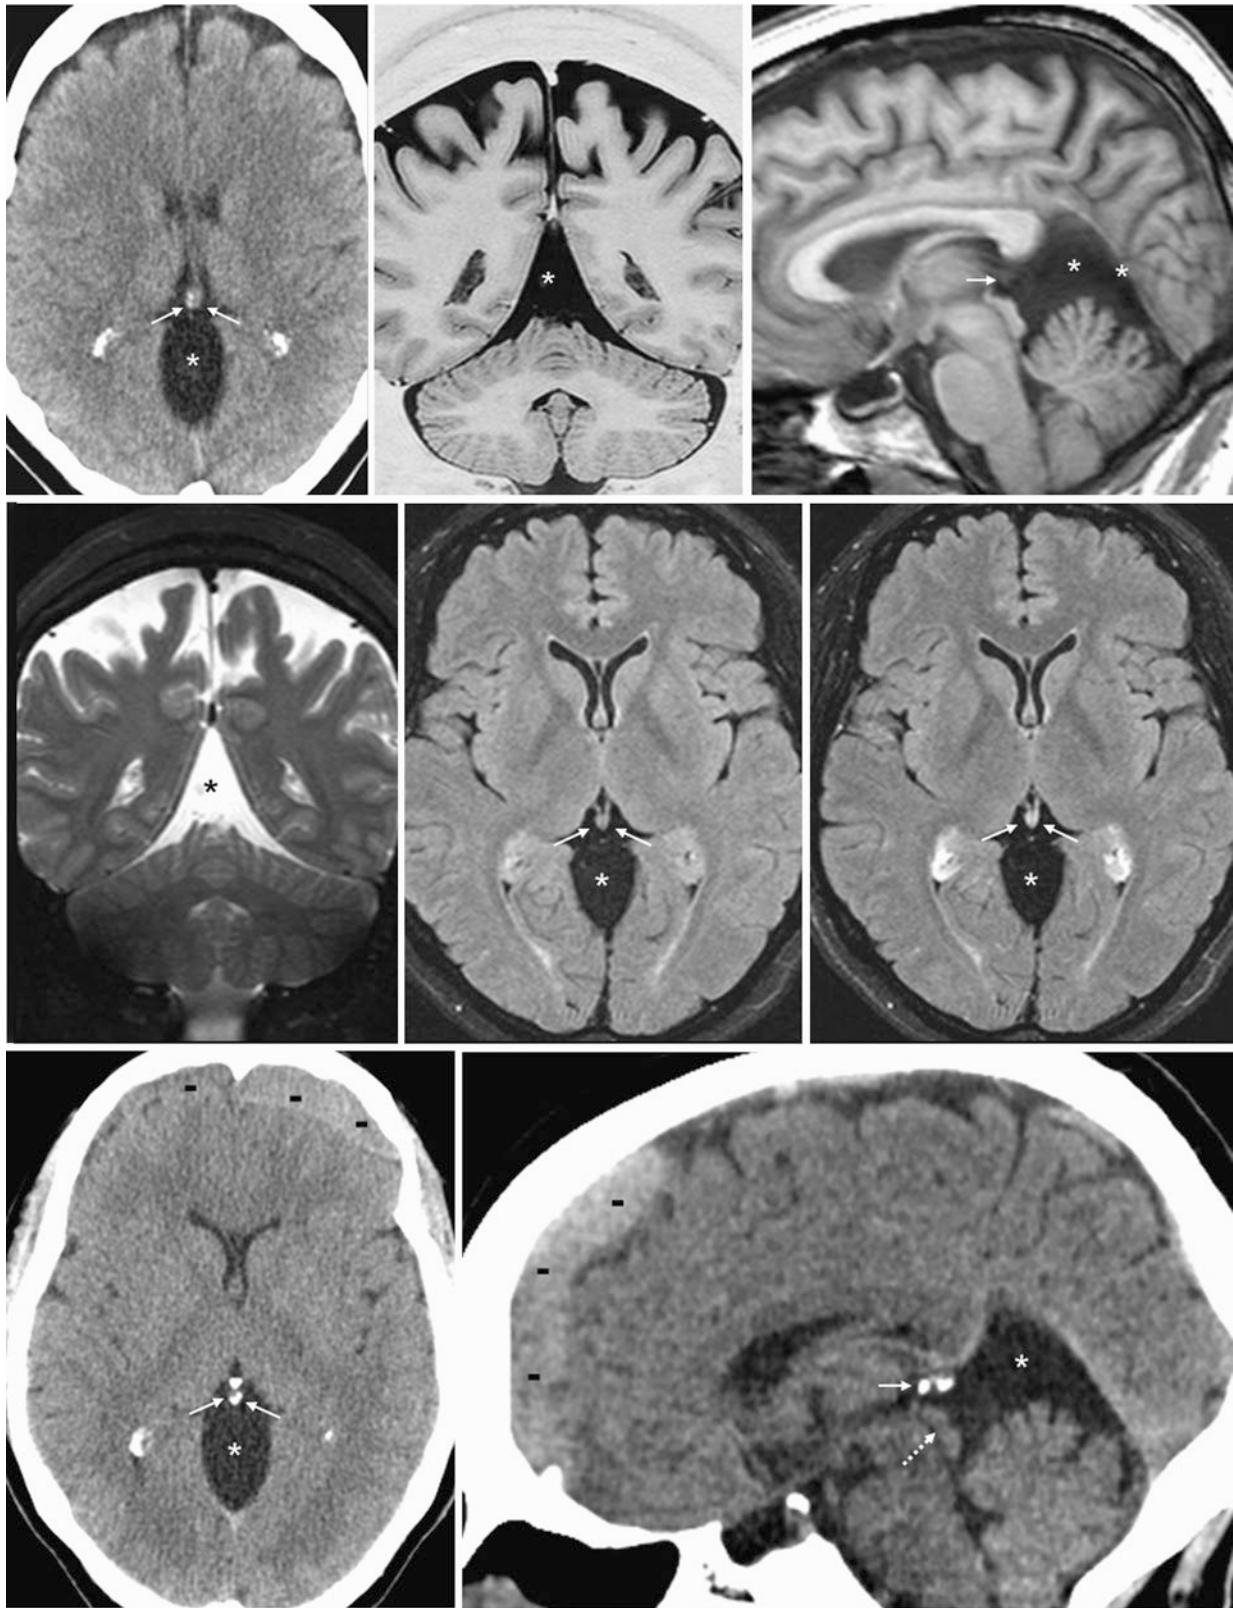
Companion case of an arachnoid cyst. The patient was a 31-year-old post-trauma individual. *Top row*: a NECT (*left*) was negative for hemorrhage, but a pineal cyst was questioned because a cyst (*) was visible above the vermis. However, the cyst appeared to be posterior to the pineal calcifications (*thin arrows*). On a 1.5 T MRI, coronal T1WI (*middle*) and sagittal T1WI (*right*) confirmed the location of the lesion. *Middle row*: coronal T2WI (*left*) and axial precontrast FLAIR
